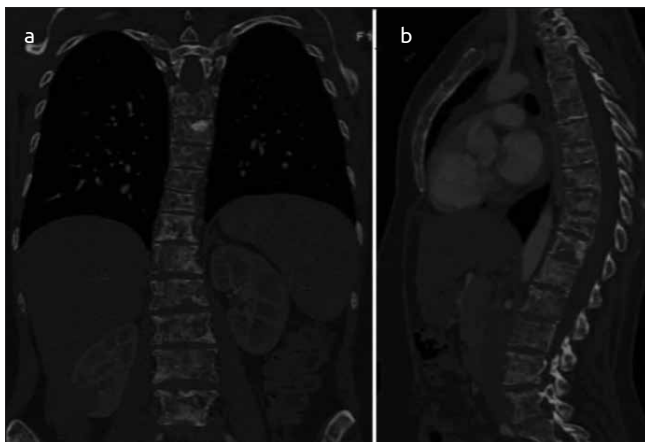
a, b. Diffuse osteoblastic and osteolytic metastatic lesions of the vertebrae and sternum are observed on the coronal (a) and sagittal (b) reformatted computed tomography fractions
